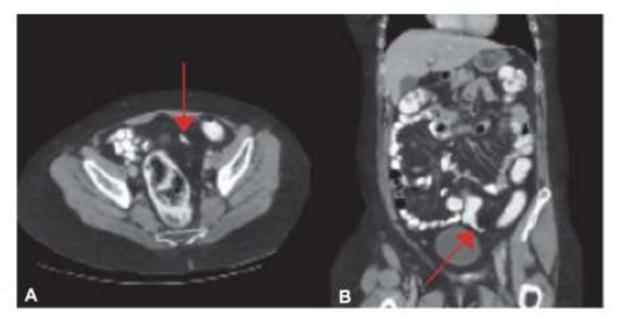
Computed tomography scan using rectal contrast showing a rectoneovaginal fistula (*arrow*) of the penile skin–lined neovagina in a 26-year-old transgender woman. Depicted are transverse (A) and coronal (B) planes.
